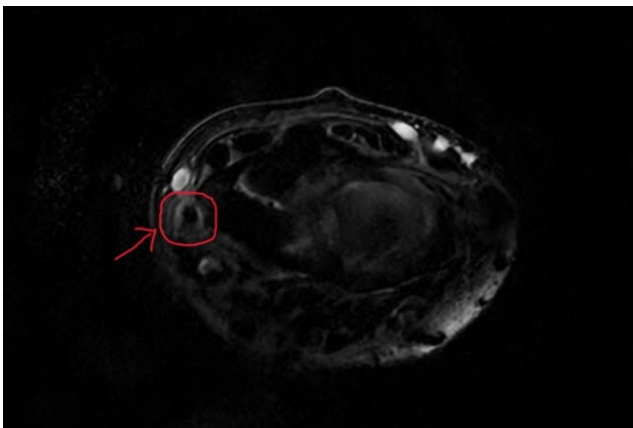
MRI indicated inflammation of the extensor pollicis brevis tendon sheath
